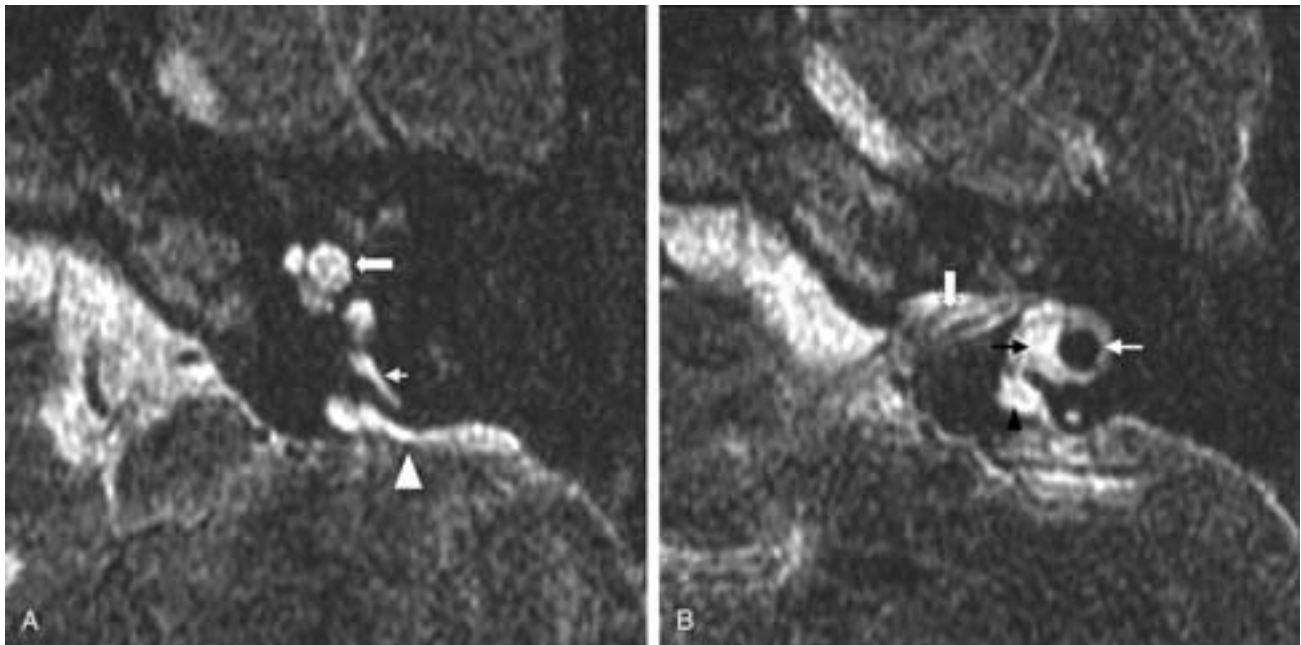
Mondini malformation. A, High-resolution axial T2-weighted MR image showing dilated endolymphatic sac (*white arrowhead*) and sac-like representation of the second and third cochlear turns (*white block arrow*) and normal posterior semicircular canal (*small white arrow*). B, More cephalad image showing the dilated endolymphatic duct (*black arrowhead*) extending to the dilated vestibule (*black arrow*). Also note the normal lateral semicircular canal (*white arrow*) and IAC (*white block arrow*).
